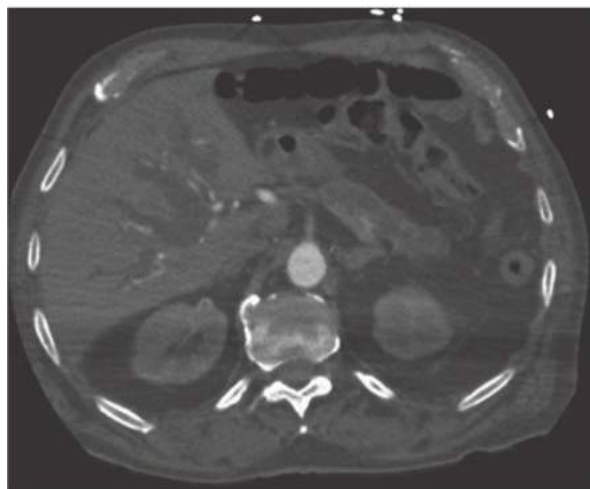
• Axial CT image with marked intrahepatic biliary ductal dilation and pancreatic ductal dilation.
